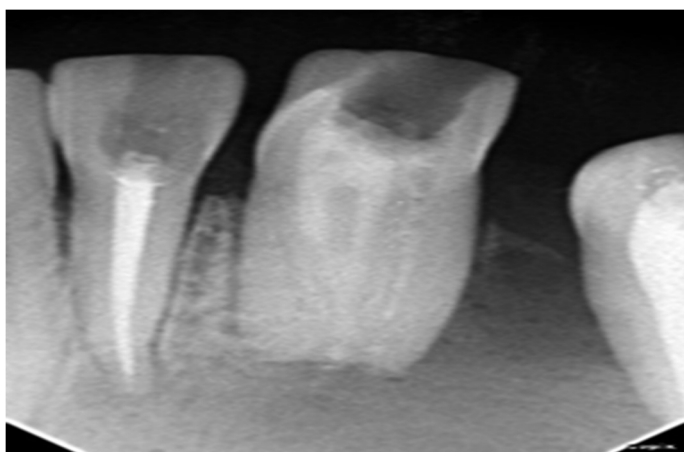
Intraoral periapical radiograph showing calcium hydroxide as intracanal medicament.
